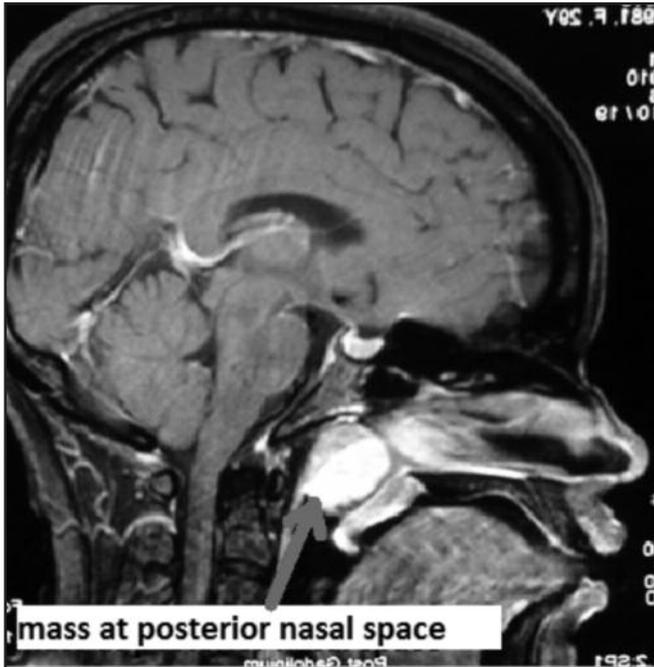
MRI base of skull and neck of patient showing mass at the posterior nasal space.
